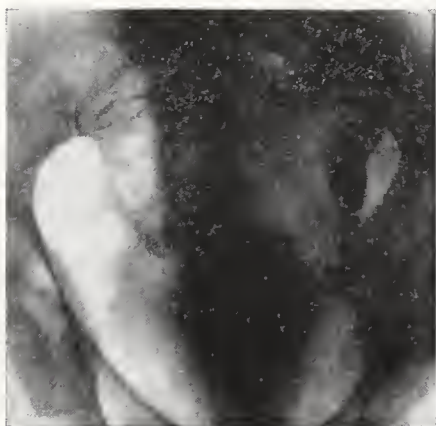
(Mr. J. G., age sixty).—Bladder markedly contracted and irregular in outline. Diagnosis: Carcinoma of the bladder. Treatment: Radium and deep x-ray therapy.
